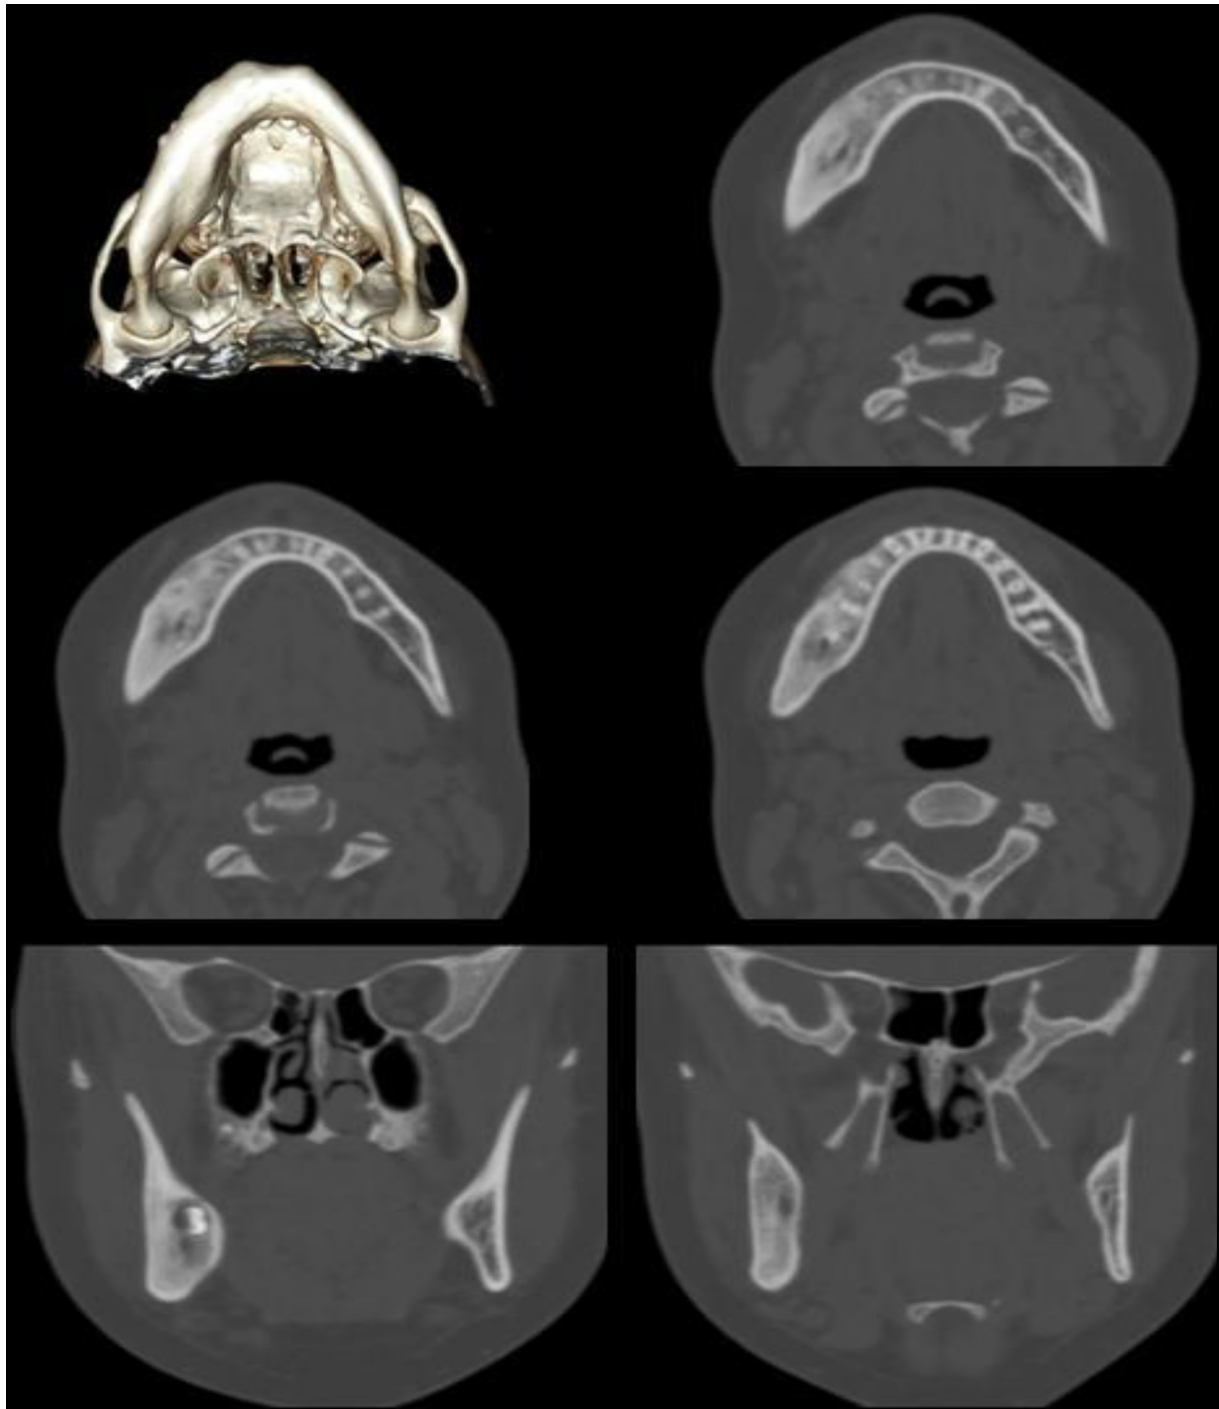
3D model reconstruction shows asymmetry due to the expanded right ramus and the body of the mandible. CT axial views and coronal MIP reconstructions demonstrate lesions typical neither for FD nor chronic osteomyelitis. The mixed appearance is like “ground-glass” with proliferative periostitis and small “lytic” lesions
